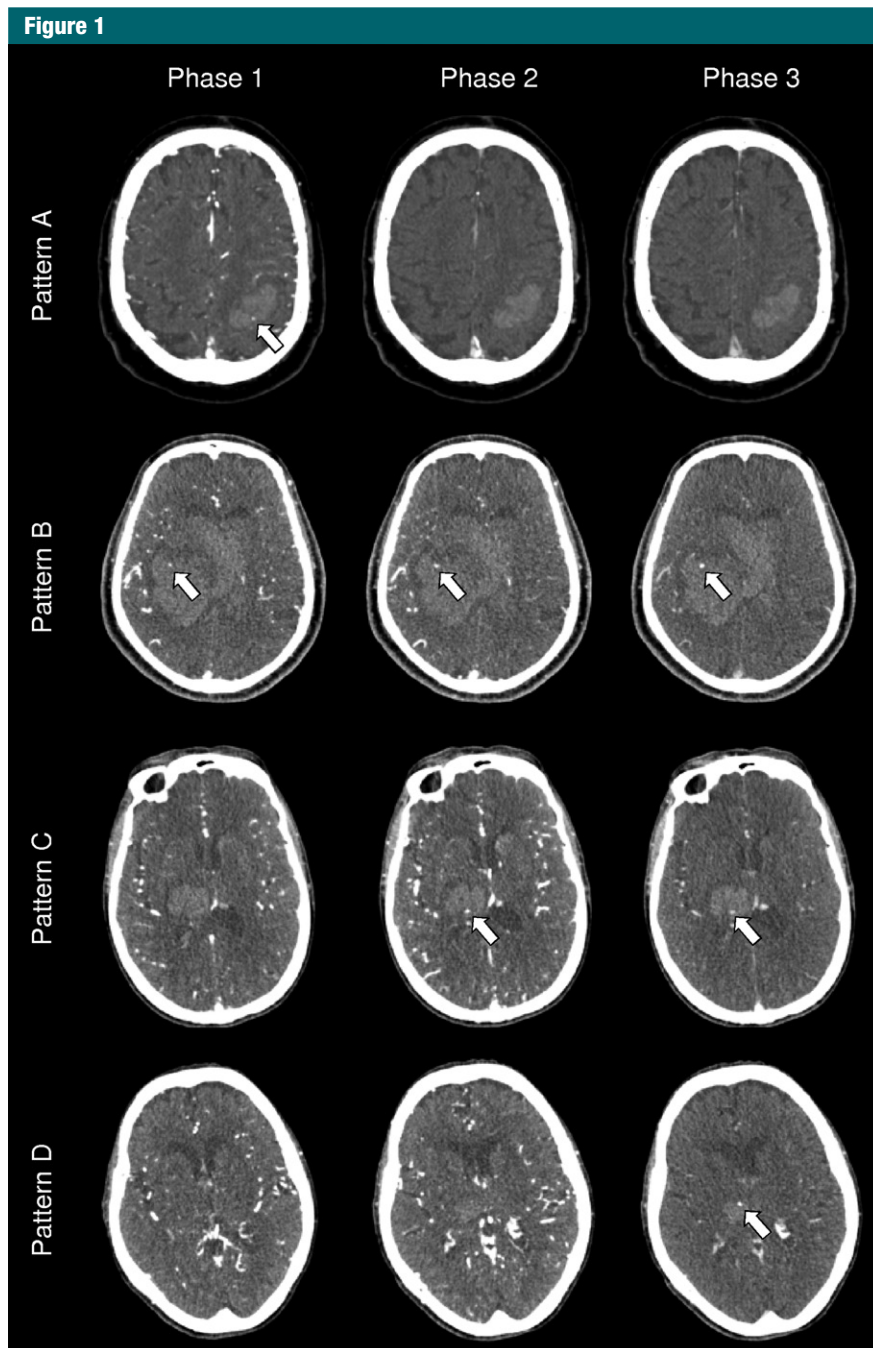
Representative images from CT angiography show the four patterns of spot sign presentation (patterns A, B, C, and D) according to presence of spot sign (arrows) in the three phases of multiphase CT angiography.
